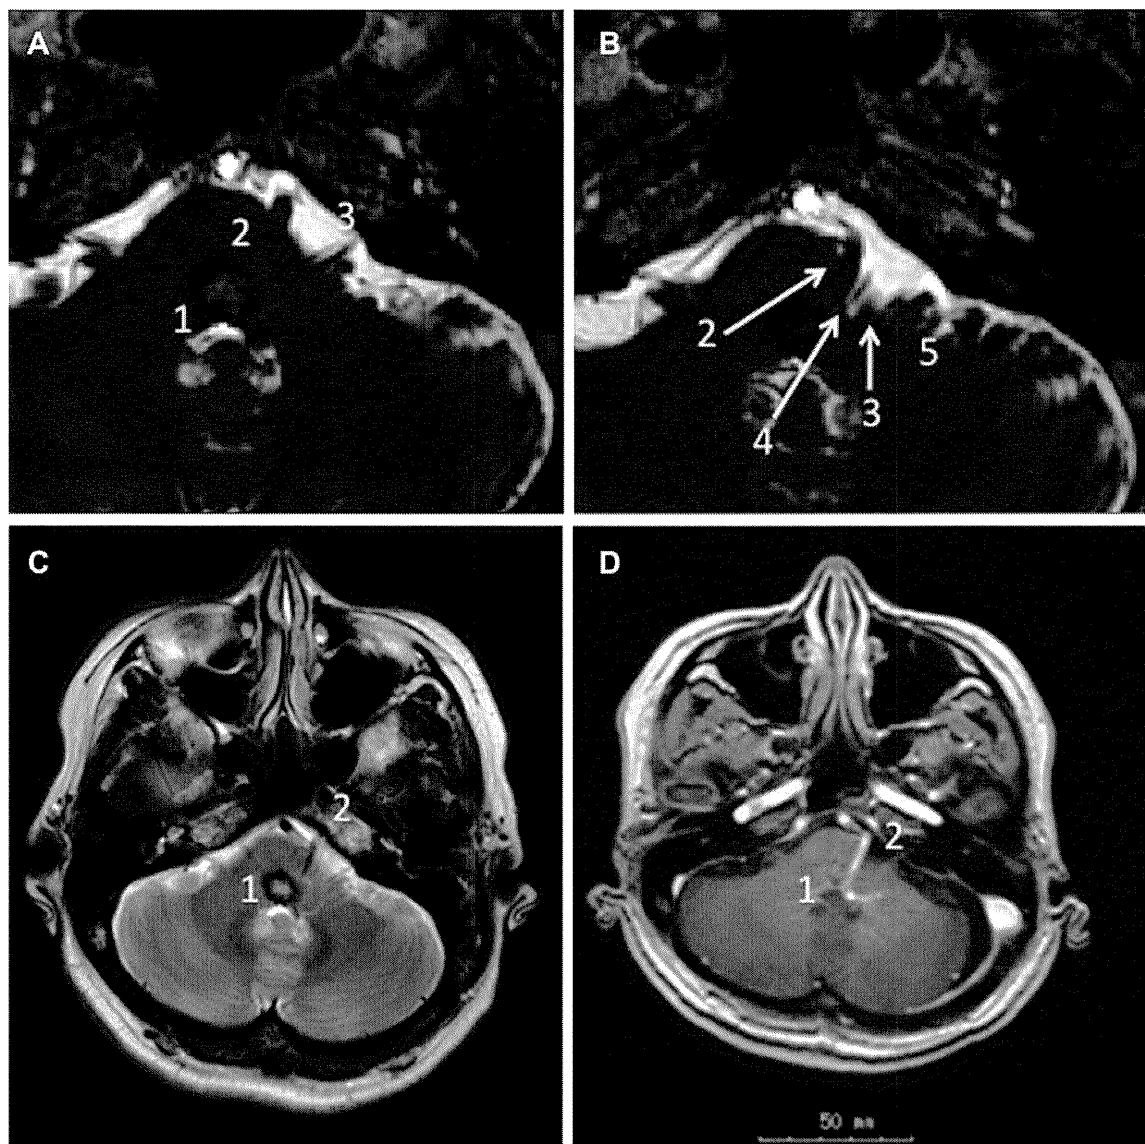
Preoperative MR images. (A, B) Axial constructive interference in steady state (CISS) images. (C) Preoperative axial T2-weighted image. (D) Postcontrast axial T1-weighted image showing venous angiomas into which the pontine cavernous angioma drained: (1) cavernous angioma, (2) venous angioma, (3) facial nerve, (4) anterior inferior cerebellar artery, and (5) flocculus.
